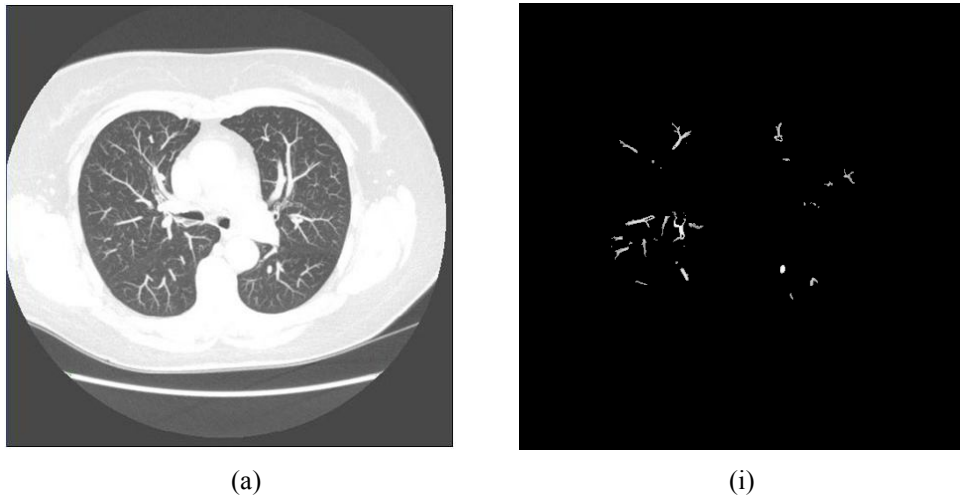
(a)-(e) Consecutive HRCT slices (i)-(v) Combined α -images processed by centroid and intensity based filtering processes
